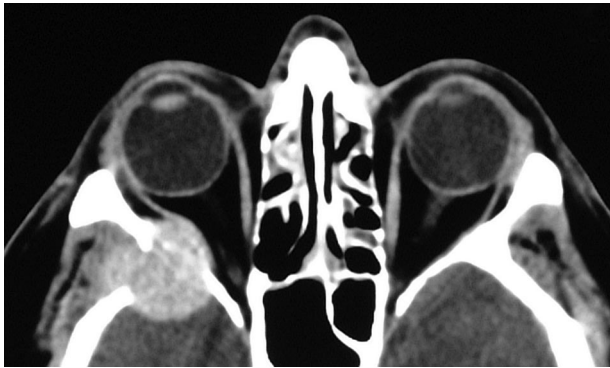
Axial CT scan, soft-tissue window, at the level of the globe demonstrating a 2 × 2 cm soft tissue mass eroding through the right lateral orbital wall and abutting the lateral rectus muscle.
